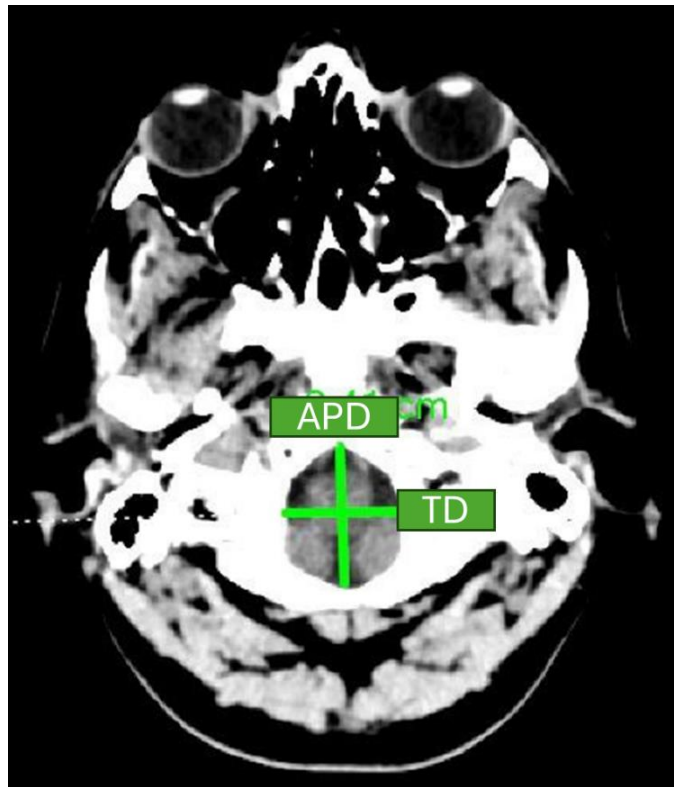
CT scan axial view showing the foramen magnum (FM). APD: Anteroposterior diameter — the maximum length of the FM measured from the basion to the opisthion in the midsagittal plane. TD: Transverse diameter — the maximum width of the FM, defined as the largest distance between its lateral margins, measured perpendicular to the midsagittal plane.
